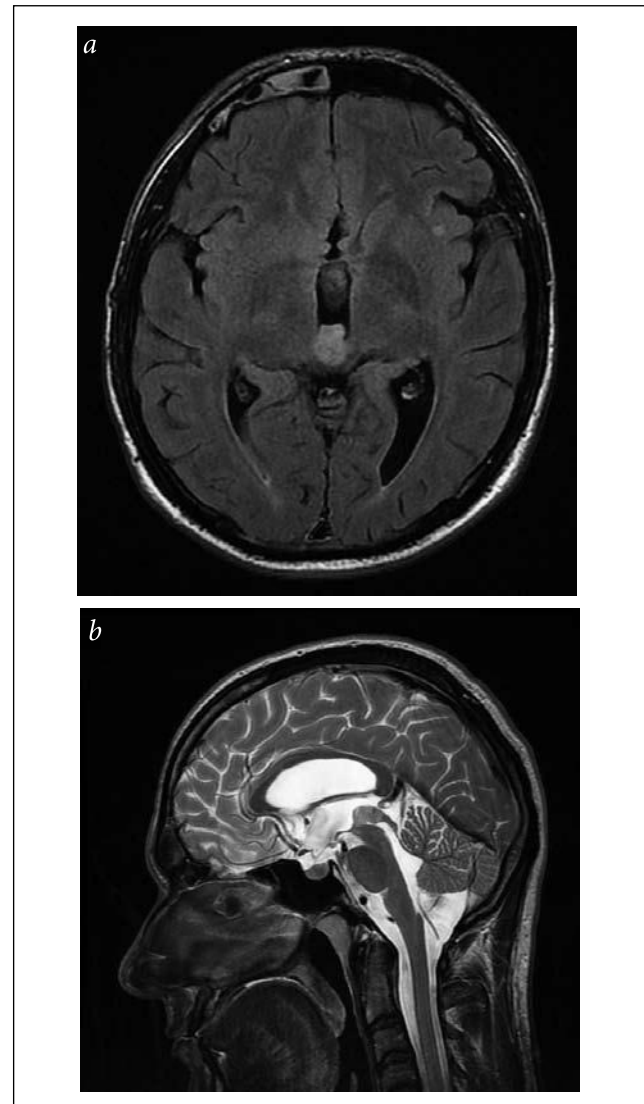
A 20-year-old man at the moment of this follow-up examination of the benign midbrain tegmental tumor, which was diagnosed at the age of 16 on MRI study performed because of headaches. The tumour was then accompanied by active hydrocephalus. Ventriculo-peritoneal shunt was implanted. The tumour is followed on MRI and does not show progression.
